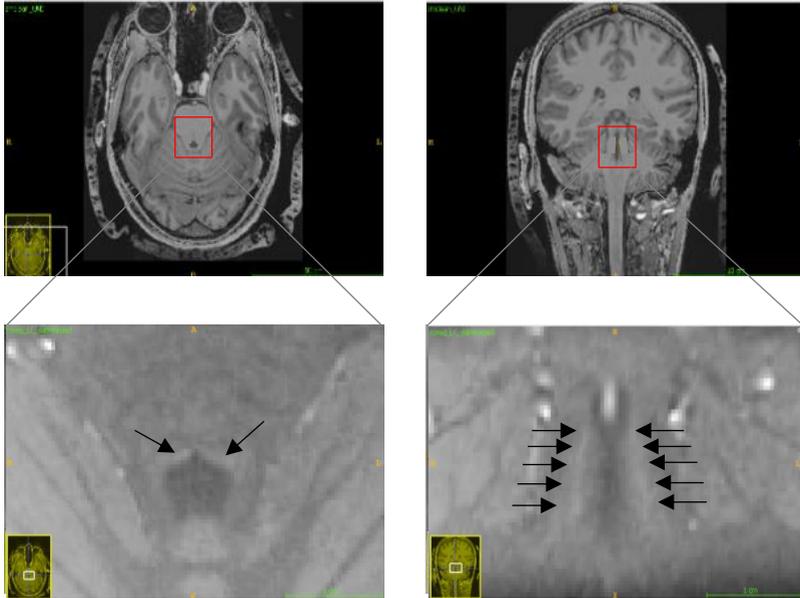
Visualization of human LC using an LC-specific MRI sequence.
